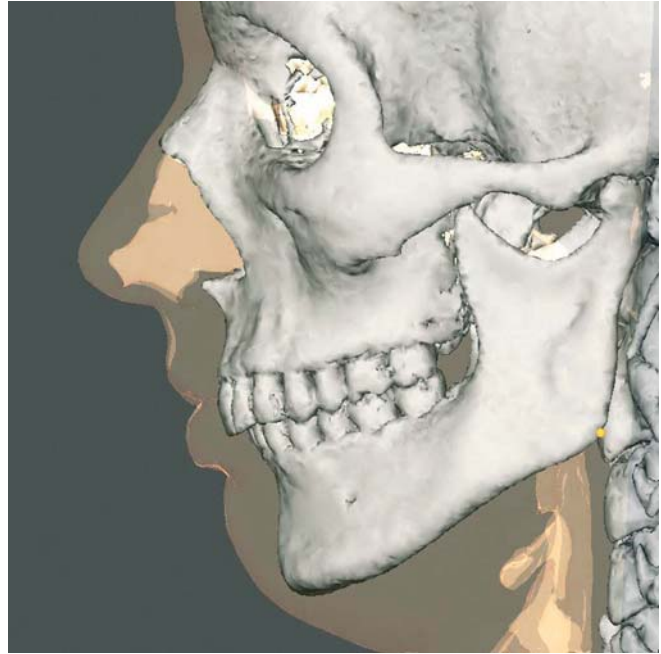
Soft tissue gonion_l. Profile view left (3-D CT, transparent soft tissues, patient K.C.)
